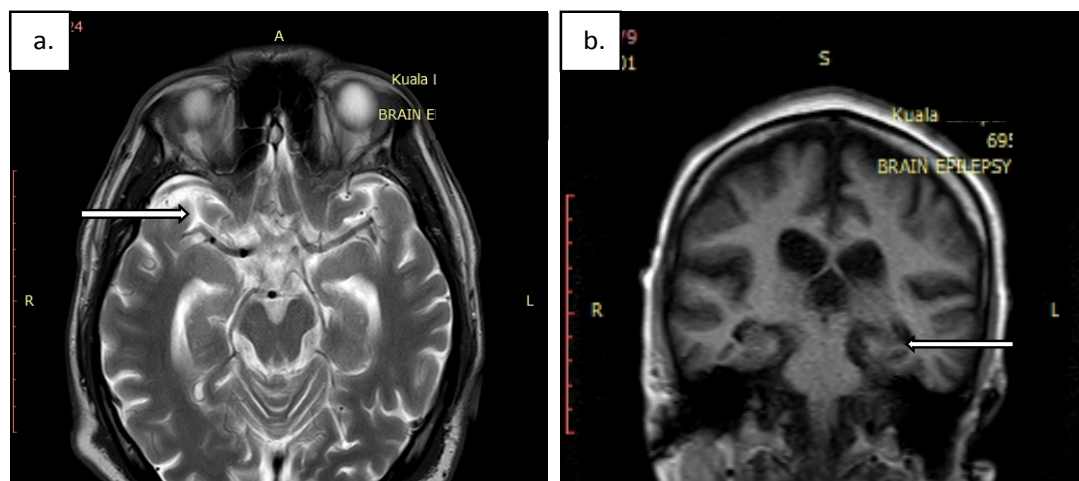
a, MRI in axial T2-weighted image. b, MRI in coronal T1-weighted image. Both a and b showed generalized cerebral atrophy with proportional hippocampus and amygdala volume reduction (arrow).
